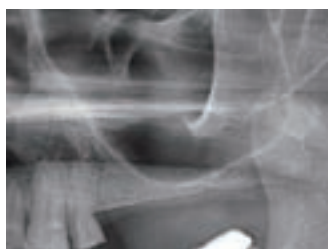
Case 4 presurgical radiographic image of left maxillary sinus.
